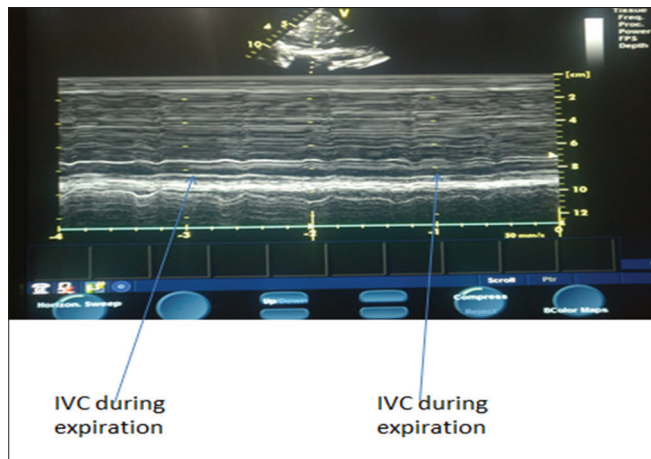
Ultrasonographic view of inferior vena cava (IVC) in longitudinal section at 2 cm distal to the junction of IVC and right atrium (top). M-mode scan of IVC with variation in the internal diameter with inspiration and expiration (bottom)
